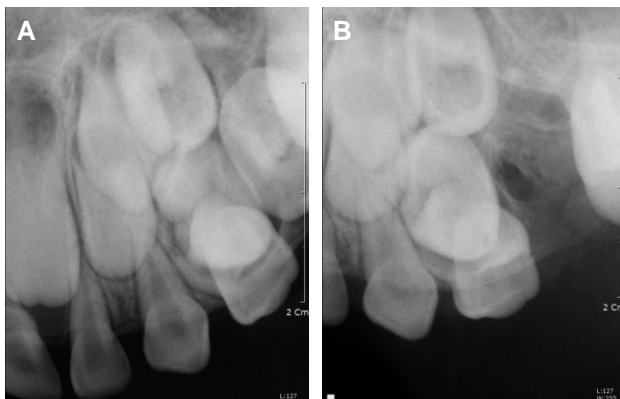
Periapical view. Before (A) and after (B) surgical removal of ankylosed primary molar. Mesiopalatally positioned second premolar tooth germ is seen.
